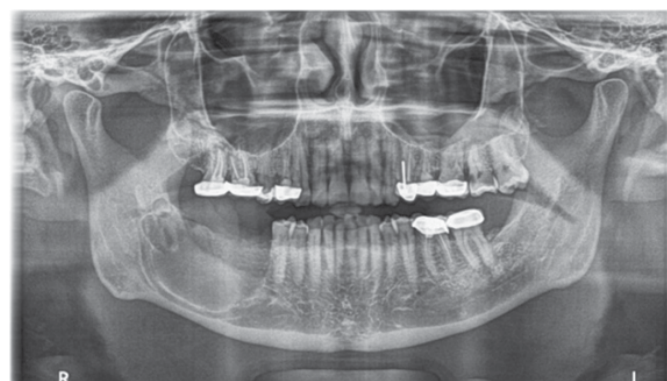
Two weeks follow-up radiograph.
